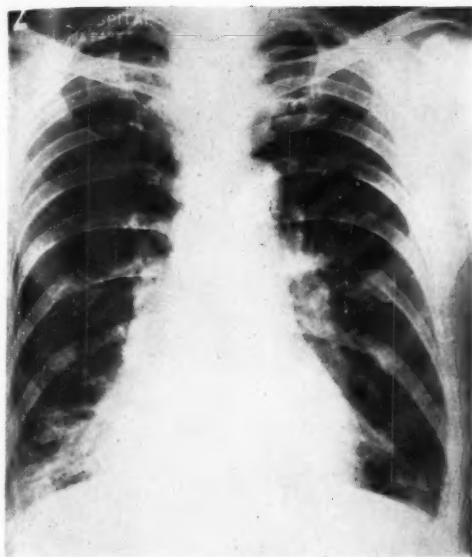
P.A. X-ray of chest showing infection at right base.
